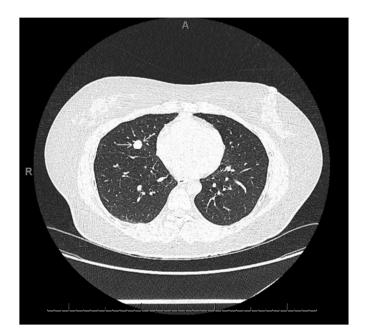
CT Scan. $1.3 \times 1.2 \times 0.8$ cm pulmonary nodule of the right middle lobe.
